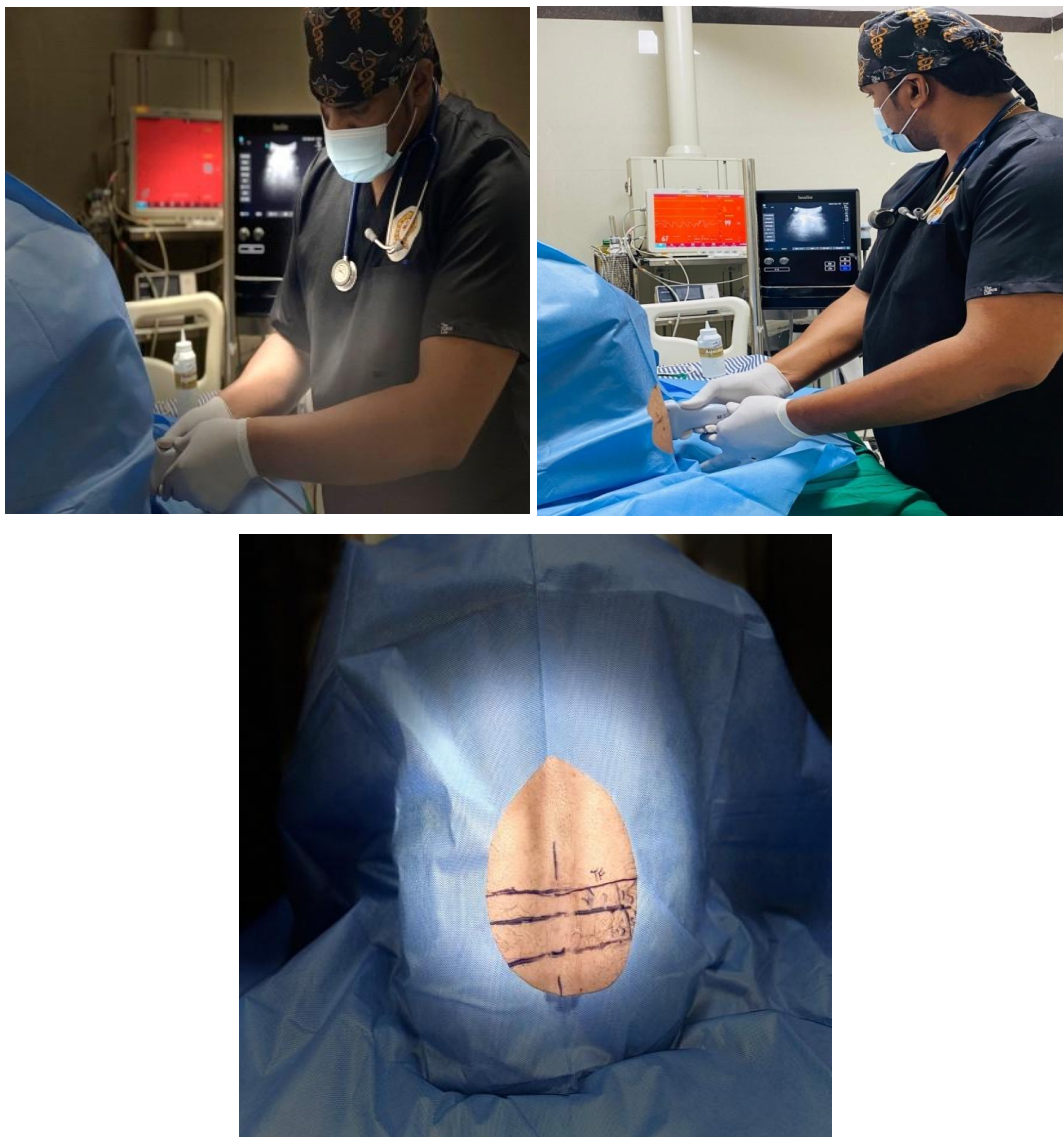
Ultrasound guided assessment of Tuffier's line distance from L4-L5 interspace.
